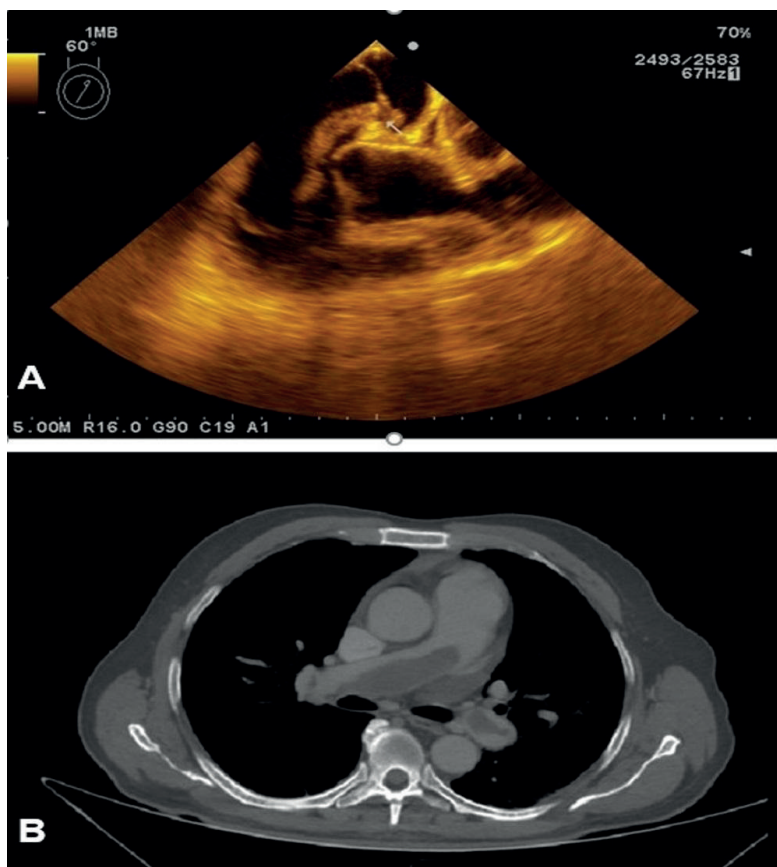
A. Transesophageal echocardiogram at 60° showing a serpentine thrombus in the right atrium (RA) traversing the interatrial septum (IAS) through the foramen ovale (FO) and entering the left atrium (LA). B. Contrast-enhanced chest CT scan showing thrombus in both the right and left pulmonary arteries, occupying nearly the entire lumen of the vessels
